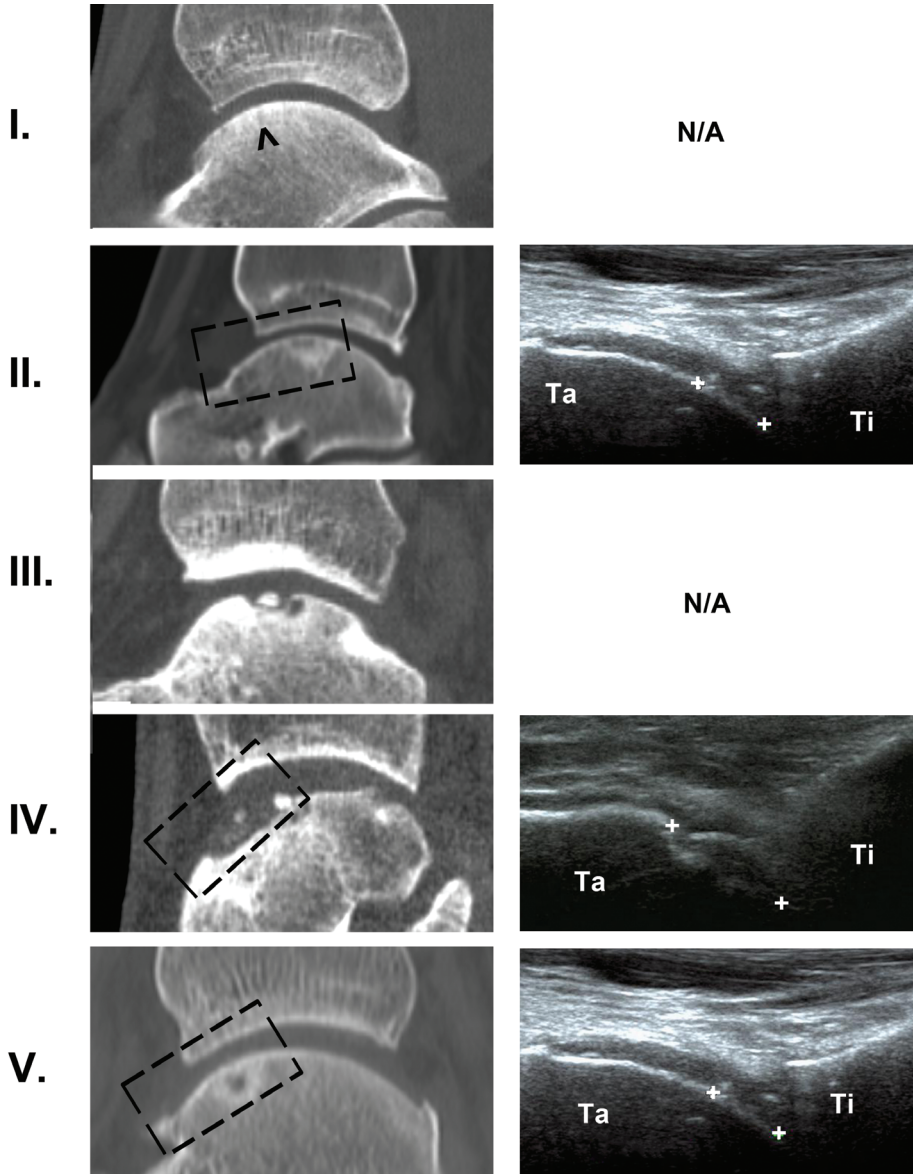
Comparison between computed tomography (CT) and ultrasound (US) images sorted on the basis of the Loomer classification.
